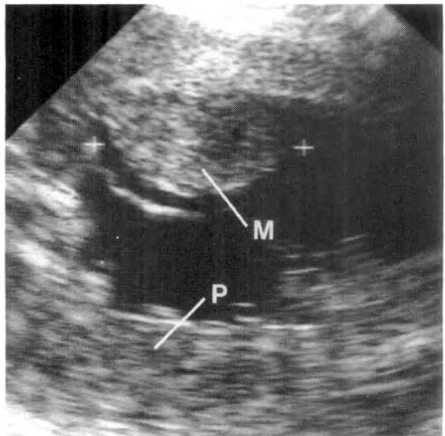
Sonogram made at 31 weeks shows a solid-appearing mass (M) on anterior myometrial surface, adjacent to margin of placenta (P). This mass, which was initially confused for a chorioangioma, proved to be a marginal placental abruption at delivery.
